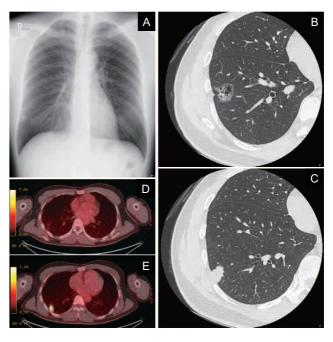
Radiographical appearance of the two lung lesions. (A) Chest radiograph showing the opacity in the right lower field. (B) Chest CT scan showing right lung lesions in S8/9. (C) Chest CT scan showing right lung lesions in S9. (D) FDG-PET scan showing low accumulation in the S8/9 lesion. (E) FDG-PET scan showing high accumulation in the S9 lesion.
